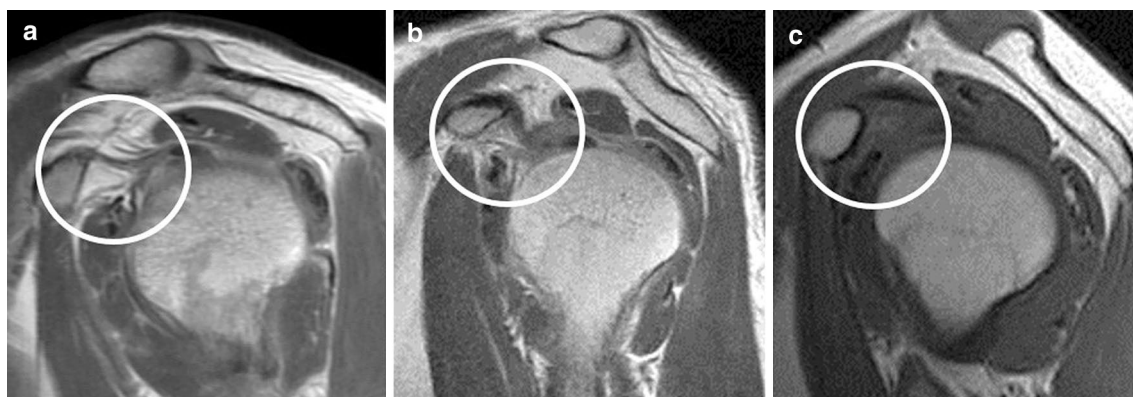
Finally, the soft tissue thickness of the rotator interval was measured on sagittal T1-weighted MR images. We classified the enhancement as grade 0 if the triangular shape outlined by the coracoid process, coracohumeral ligament, and capsular membrane was
